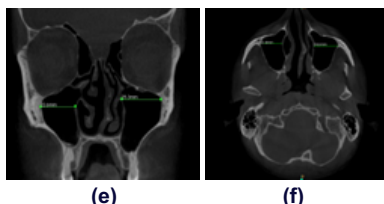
Figure (e) and (f): CBCT images showing measurement of transverse dimensions of maxillary sinus from coronal (e) and axial
